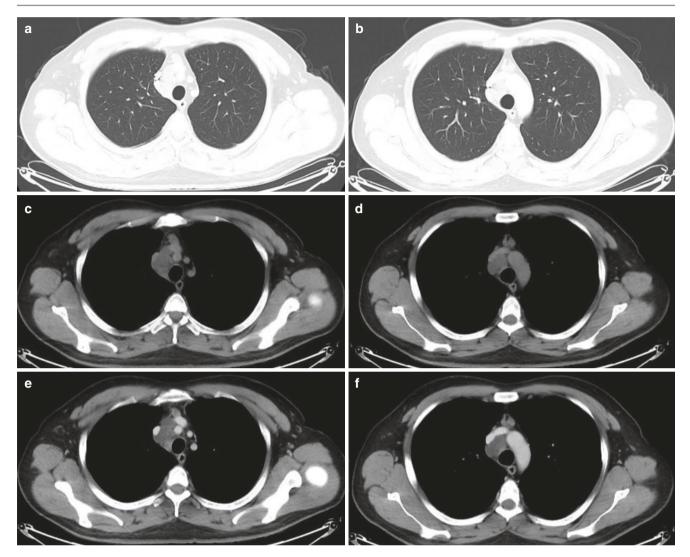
(a-f) Chest CT image of a 30-year-old man complained of chest tightness for more than 3 months
